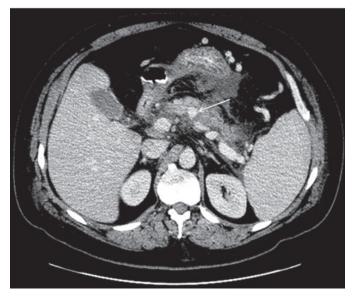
Computed tomography scan of abdomen/pelvis with contrast revealing pseudoaneurysm (arrow) located in the proximal-mid splenic artery and splenomegaly (not fully appreciated in this cut)
